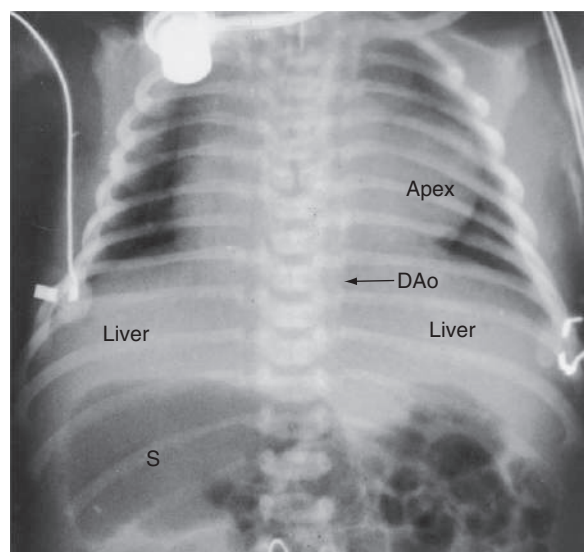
X-ray from asplenic male neonate with right isomerism. The liver is transverse, the stomach (S) is on the right, and the heart is midline, but the base to apex axis points to the left. DAo, Descending aorta. (Modified from Perloff JK, Marelli AJ. *Perloff's Clinical Recognition of Congenital Heart Disease*, 6th ed. Philadelphia: Saunders; 2012: Fig. 3-31, p. 32.)
